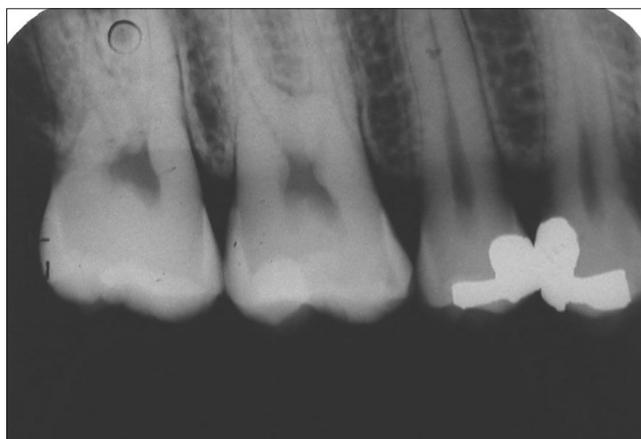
Postmortem radiograph of the same person as in Fig. 1a.
